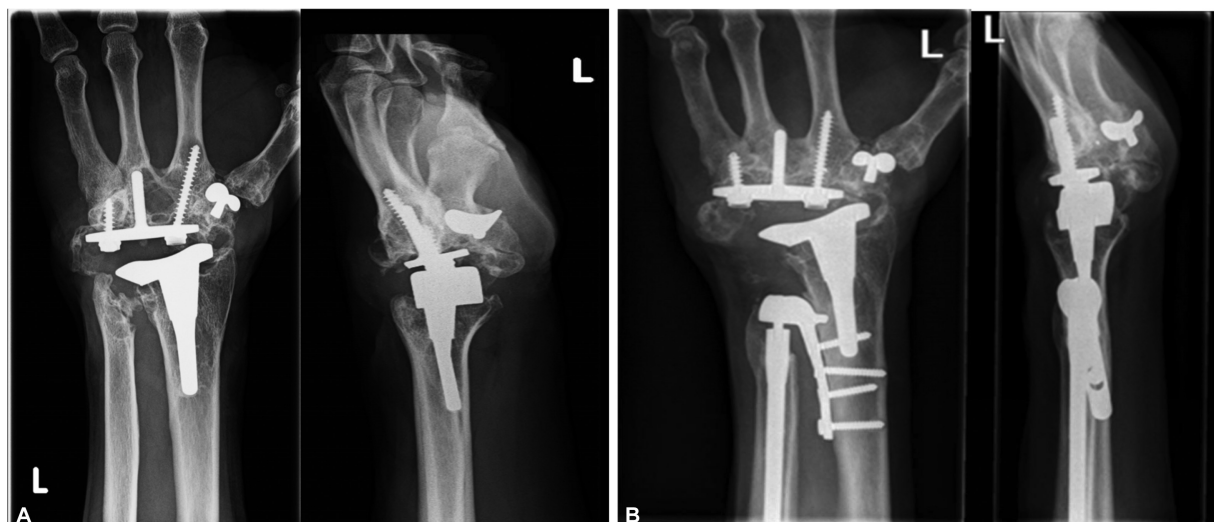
(A) Lateral and anteroposterior X-rays of case 1 before Aptis distal radioulnar joint (DRUJ) implantation. (B) Lateral and anteroposterior X-rays of case 1 after Aptis DRUJ implantation. Note the ulnar translation of the carpus.
